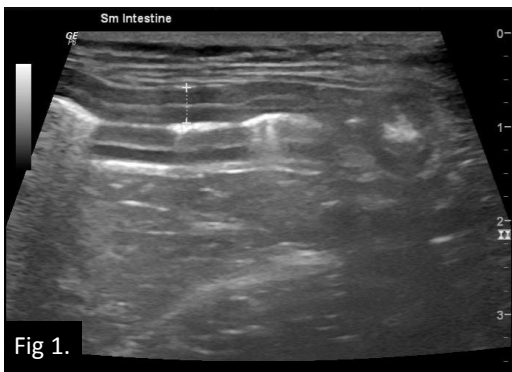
Ultrasonographic view of the intestines. Overall small intestinal wall thickness is increased at 0.38cm, with thickening of both the mucosal and muscularis layers.
